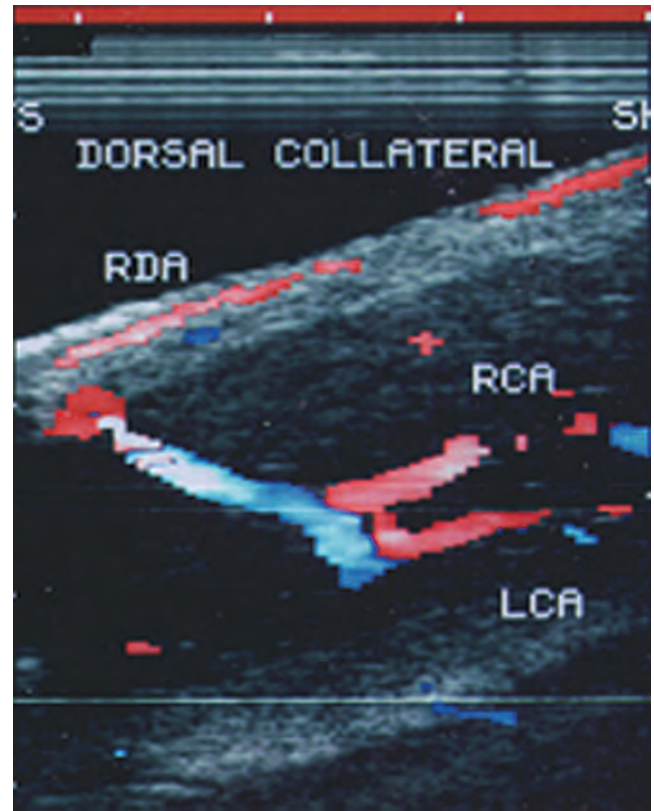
Collateral circulation connecting the right dorsal artery (RDA) to the right cavernous artery (RCA), and the left cavernous artery (LCA) is shown by color duplex ultrasonography in a longitudinal view.
